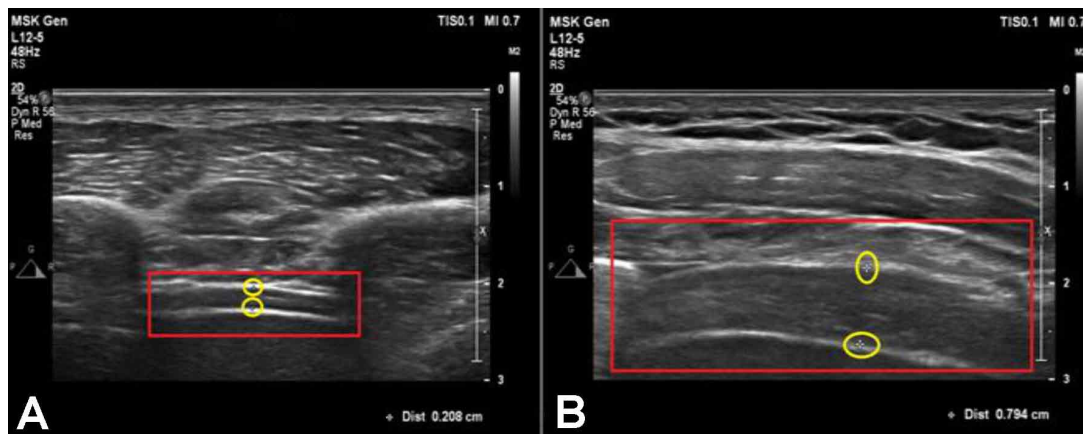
Examples of B-mode ultrasound images to assess diaphragm thickness in during expiration (a) and inspiration (b).
